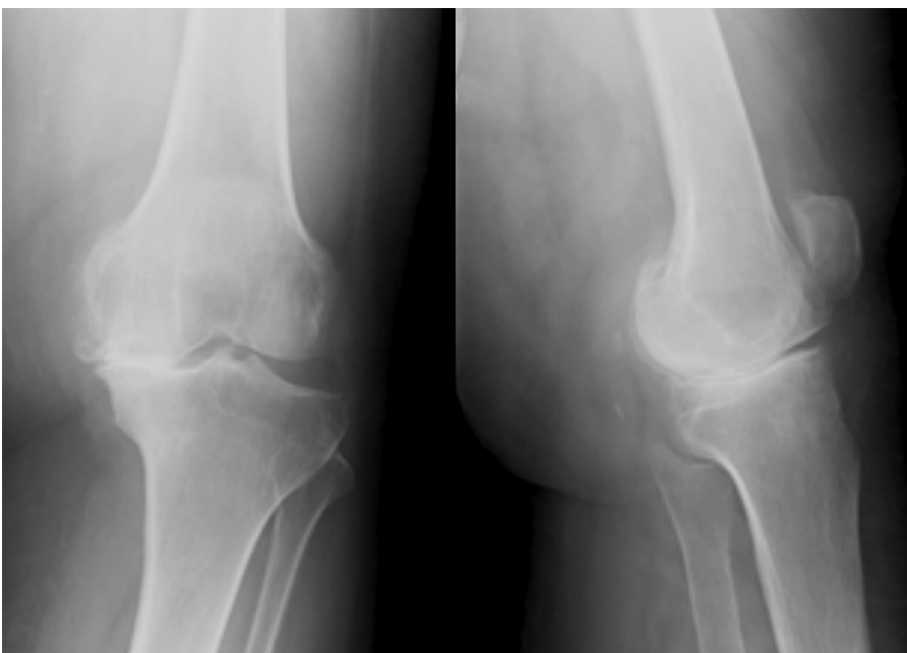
Radiographic assessment of a severely osteoarthritic knee with varus deviation. The radiograph shows the classic signs of osteoarthritis, such as osteophytes, deformity, joint space narrowing, subchondral bone sclerosis, and prominent tibial spines.
